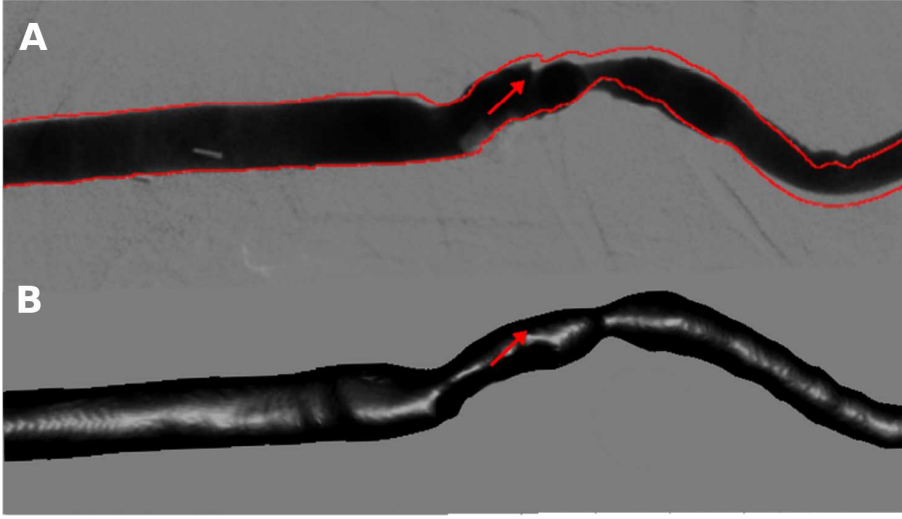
Mismatches of the pre-operative condition between conventional angiography and the reconstructed model. *A* Arterial configuration changes during contrast agent injection. The border (in red) of the vessel from angiography at a certain instant is overlaid to the angiography at a subsequent instant clearly showing the modification of the lumen shape due to loading factors. *B* The arterial geometry from the CTA is depicted. The red arrows indicates the irregularities not detected in the CTA *B*, which are visible in the angiography *A*.
